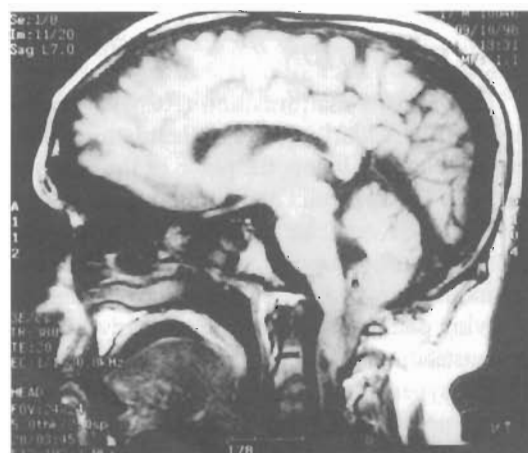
Midsagittal sections of MRI demonstrates cerebellar tonsillar herniation and cervical syrinx formation
